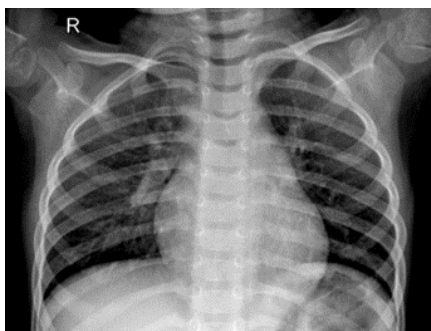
Normal X-Ray Image
